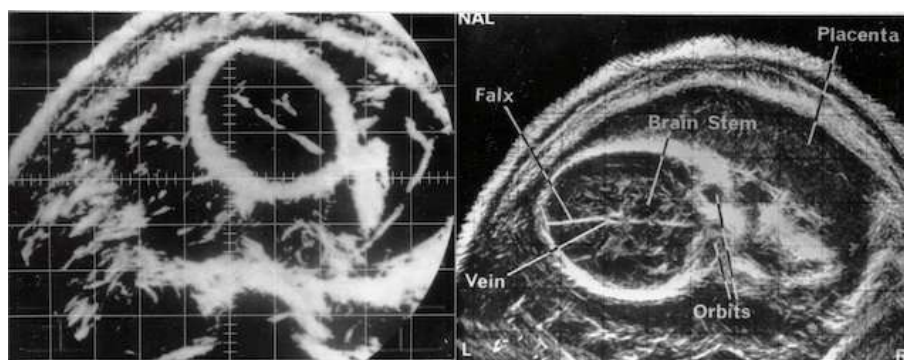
Comparison of bistable and grey-scale images. A bistable image of the fetal head is on the left, and a comparable grey-scale image on the right. Image reproduced with permission from the Australasian Society of Ultrasound in Medicine.
